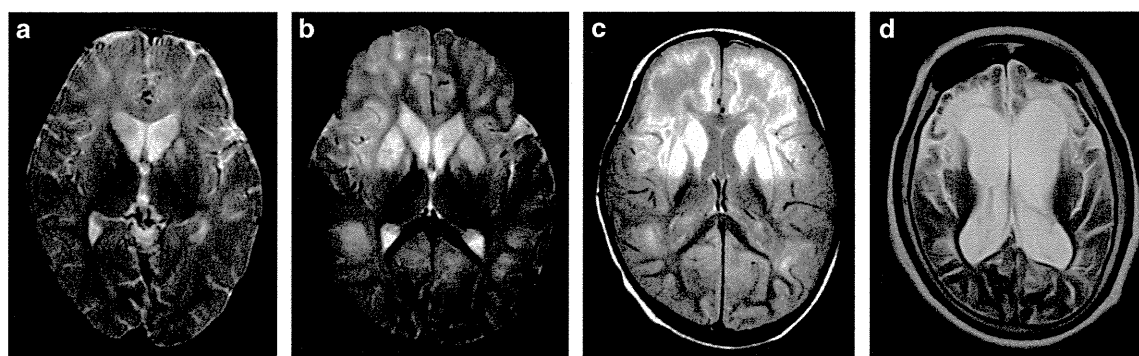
T2-weighted brain magnetic resonance imaging (MRI) of the individual with *LIAS* mutations. (a) Examined at disease onset (19 months old). High-intensity areas are present in the caudate nucleus and the putamen. (b) Seven days after disease onset. The high-intensity areas have expanded into the white matter, especially in the frontal region. (c) One month after disease onset. High-intensity areas are noted not only in the basal nucleus but also in the subcortical white matter, especially in the frontal region. (d) At 15 years old. Owing to diffuse cerebral atrophy, the lateral ventricles have expanded. White matter atrophy is predominant in the frontal region.
